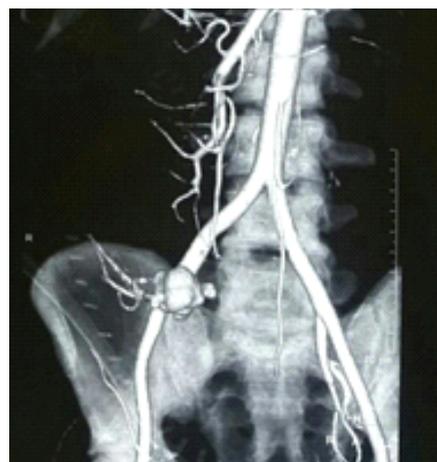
Showing Computed Tomogram angio of transplant renal artery pseudoaneurysm
